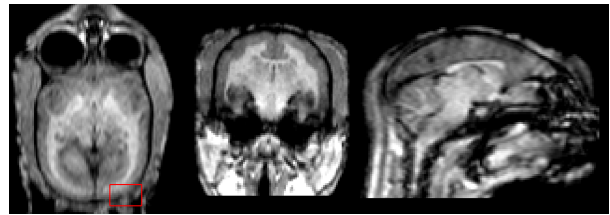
3T MRI scan of a 2-year-old marmoset (3D T1W-GRE sequence: TE = 5.2 ms, TR = 12 ms, Flip angle = 8°). The red rectangle emphasizes a region with little intensity gradients at the brain boundary.
